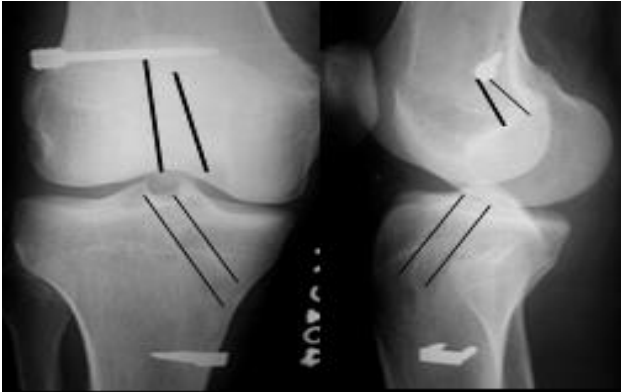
Showing the enlarged tibial and femoral tunnels marked for measurement in antero-posterior and lateral radiographs of knee joint.
